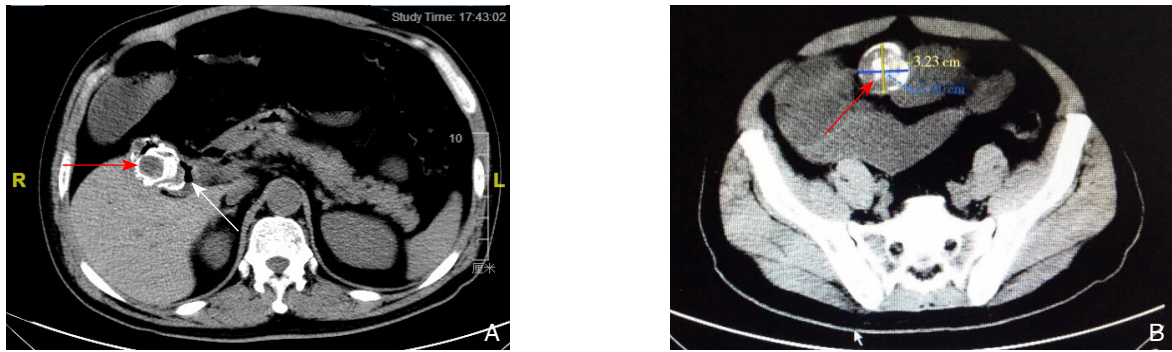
对症支持治疗 4 d 后全腹 CT 扫描显示, 胆囊内可见混杂密度影, 胆囊积气; 胆囊与临近十二指肠沟通; 回肠下段可见一结节状致密影, 与前次相比, 有明显下移 A: 红色箭头表示胆囊结石, 白色箭头表示胆囊与十二指肠瘘口; B: 红色箭头表示肠管内结石, 内径大小约 3.23 cm × 3.41 cm
